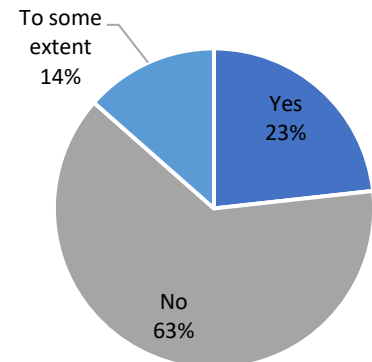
X-ray Machine Functional
